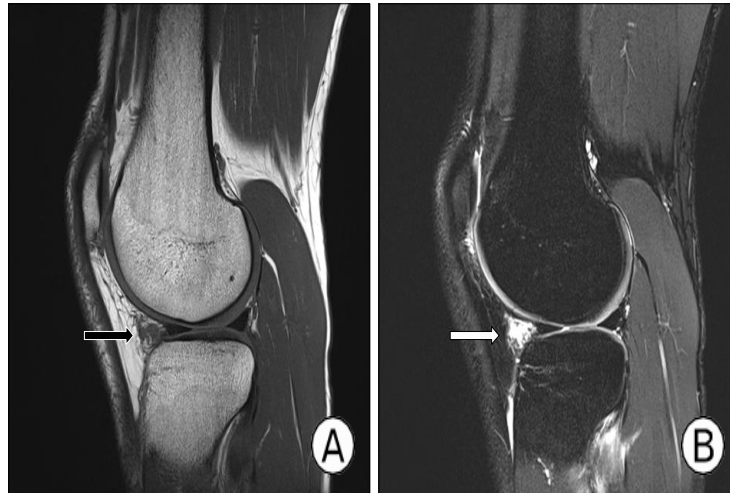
On magnetic resonance image (MRI) scan, low signal intensity in the T1-weighted sagittal image (A) and high signal intensity in the T2-weighted sagittal image (B) were observed at the infrapatellar fat pad located in the anterior part of the anterior horn of the lateral meniscus (arrow). MRIs show fluid collection anteriorly from the proximal tibia extending to the anterior horns of the meniscus.
